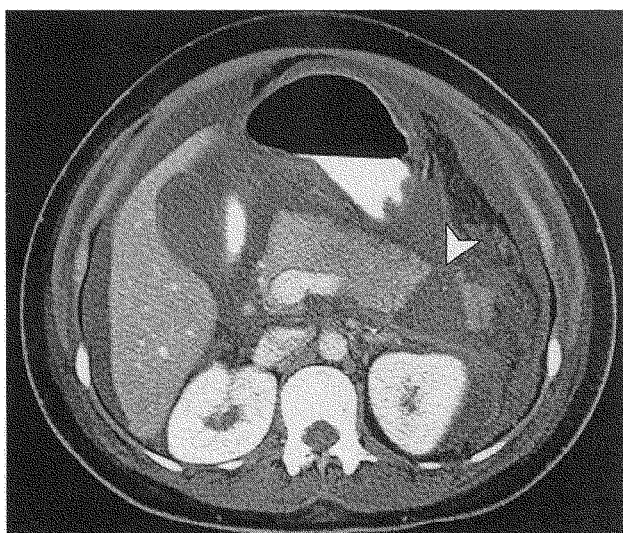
Abdominal CT scan highlights wedge-shaped defect in the tail of the pancreas (white arrow).
